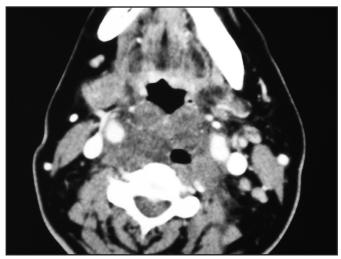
An axial CT scan showing evidence of retropharyngeal collection.
